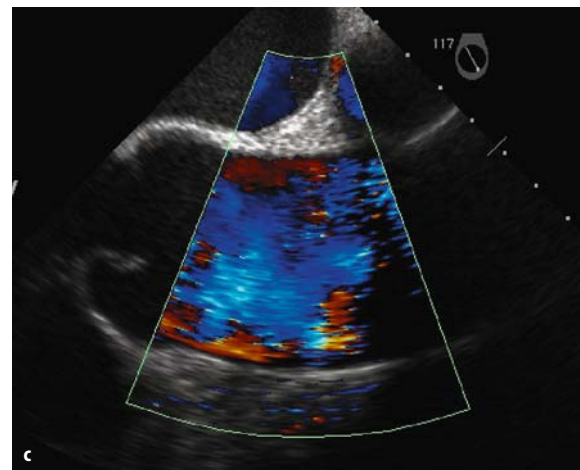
Aortic dissection. Linear artefacts into ascending aorta. a Two-dimensional long-axis view. b M mode. c Color Doppler image showing homogeneous flow
